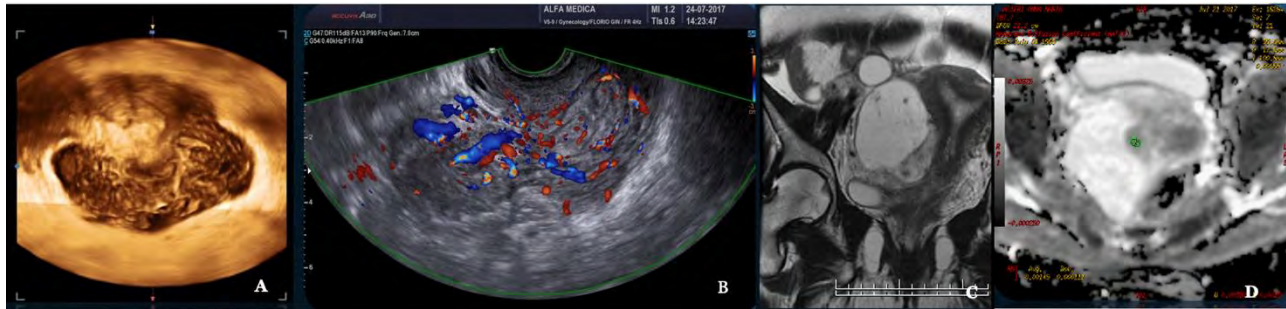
Smooth muscle Tumor with Undefined Malignant Potential (STUMP) A Three D vaginal scanning B Doppler Ultrasound ISGE US score 22/25 C MRI T2 image. D ADC Mapping ADC in the high range:  $1,1 \times 10^{-3}$
